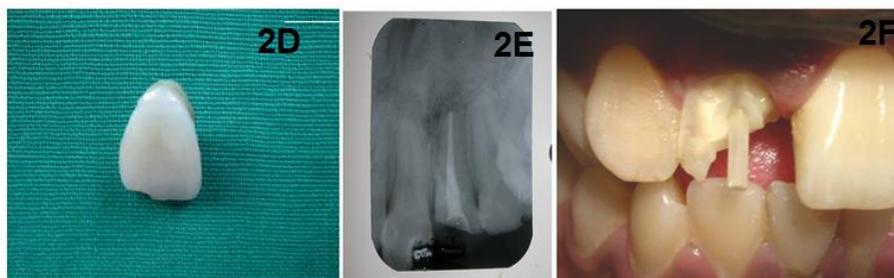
2. D) Fractured segment, E) Post obturation radiograph, F) DT post cementation
